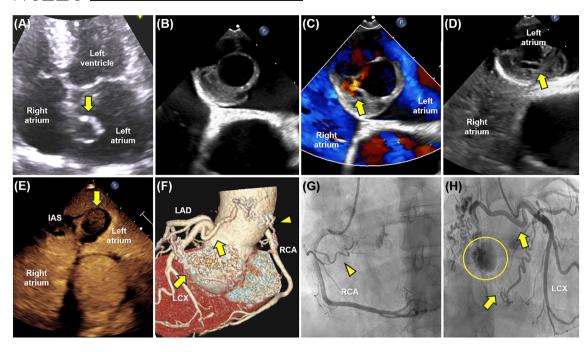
Preoperative multimodality images. (A) Transthoracic echocardiography showing a left atrial cardiac mass attached to the IAS (arrow). (B) Transesophageal echocardiography showing a cystic lesion with a solid component (arrow). (C) Color Doppler image showing the feeding arteries (arrow) flowing from the bottom of the tumor into the cystic lesion and blood flow communication in cystic mass. (D) In the agitated saline test, the microbubble was filled in the right atrium, not in the left atrium or the cystic mass (arrow). (E) In contrast echocardiography, contrast was filled in the right atrium, then the left atrium, and finally inside the cystic mass (arrow). (F) Preoperative coronary computed tomography showing three feeding vessels originating from the proximal and mid-LCX (arrow) and proximal RCA (arrowhead). (G) and (H). Coronary angiography showing one feeding vessel from the RCA (arrowhead) and two from the LCX (arrow), as well as a vascular blush in the tumor (circle). IAS, interatrial septum; LAD, left anterior descending artery; LCX, left circumflex artery; RCA, right coronary artery.
